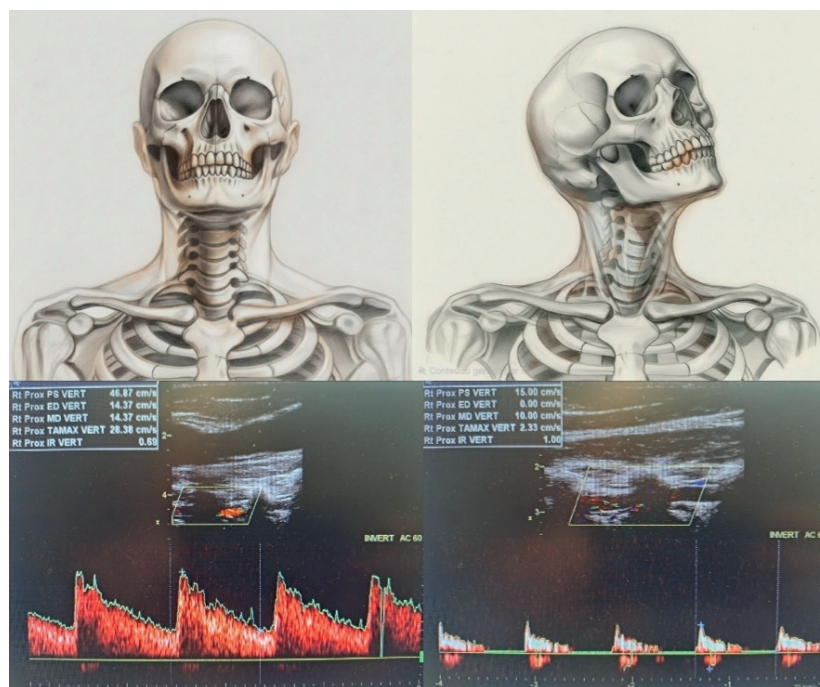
Vascular Doppler of the V2 segment performed in the neutral position (left), demonstrating normal flow; on the right, the same patient shows staccato-pattern flow after contralateral rotation maneuver.
